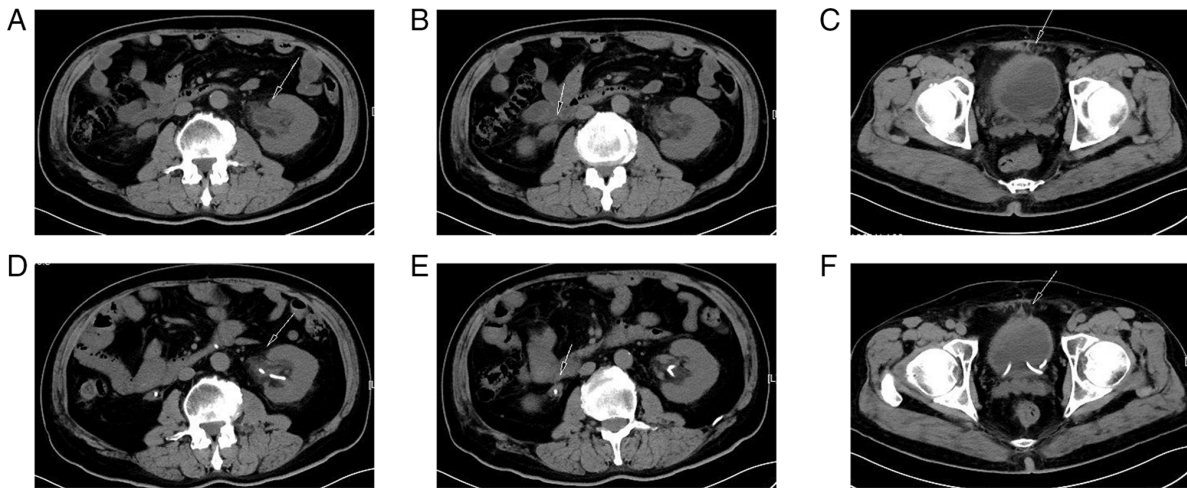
Comparison of urinary system CT findings before and after glucocorticoid therapy. (A-C) CT images of the urinary system obtained in April 2025, prior to initiation of glucocorticoid treatment, showing bilateral hydronephrosis, ureteral dilation and bladder wall thickening (black arrow). (D-F) CT images in June 2025 following glucocorticoid therapy, demonstrating marked resolution of hydronephrosis and ureteral dilation, along with improvement in bladder wall thickening (black arrow).
